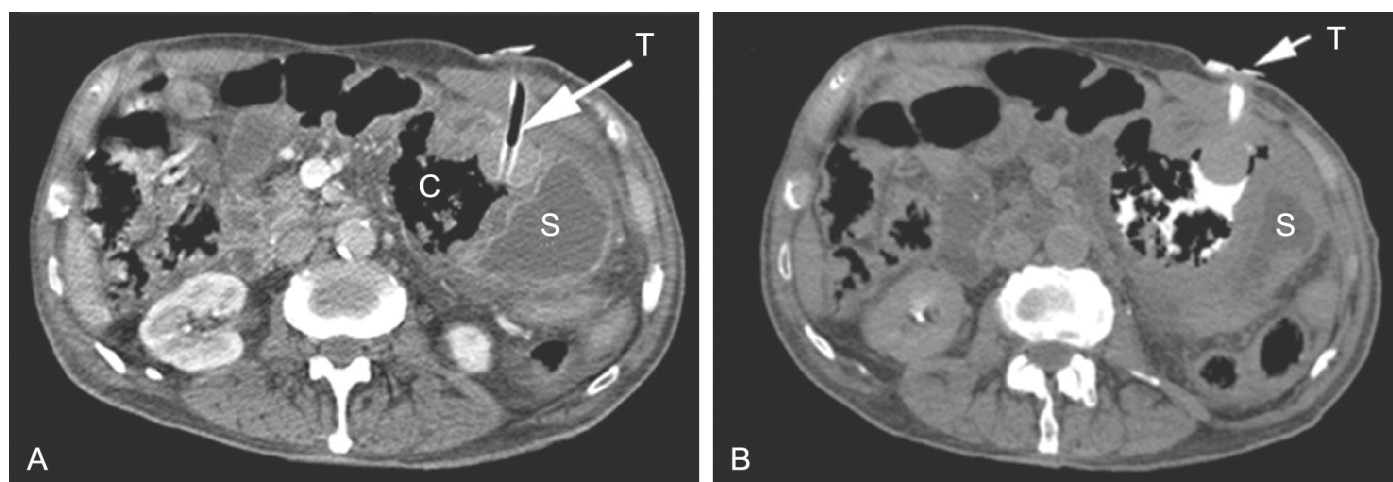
Abdominal CT. A – The extremity of the feeding tube (T) inserted within the abdominal collection (C), which displaced the stomach (S) to the left; B – Contrast medium filling the abdominal collection after the injection through the feeding tube.
